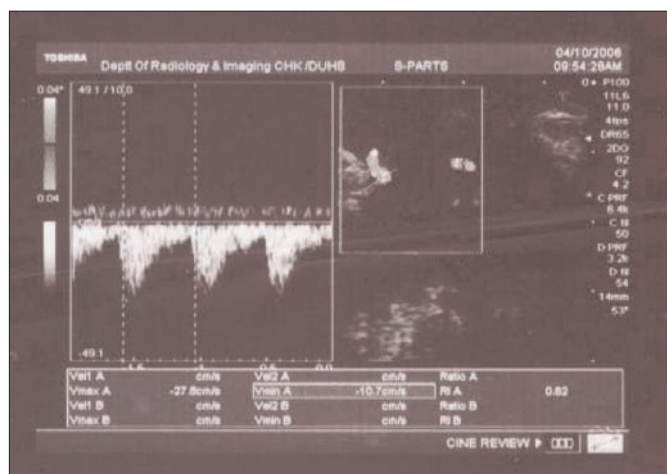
A solid malignant lesion showing type 3 vascularity on Doppler ultrasound with moderate resistance flow.
